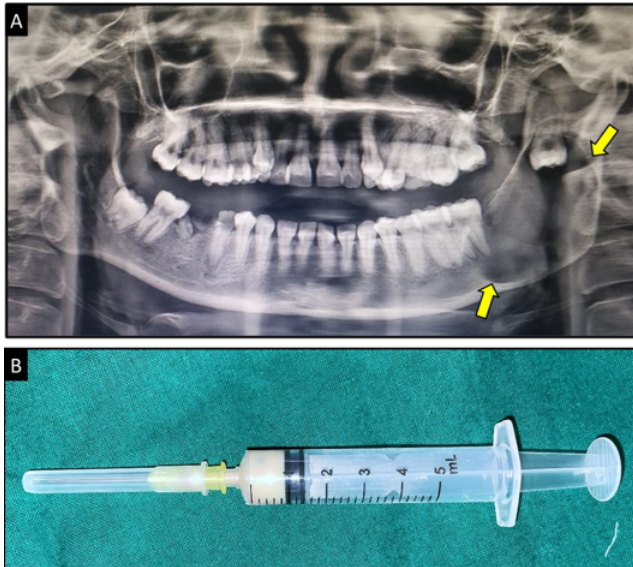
A: Orthopantomogram showing a well-defined unilocular radiolucent lesion with severely displaced mandibular left third molar; B: Creamy aspirate obtained from the lesion.
